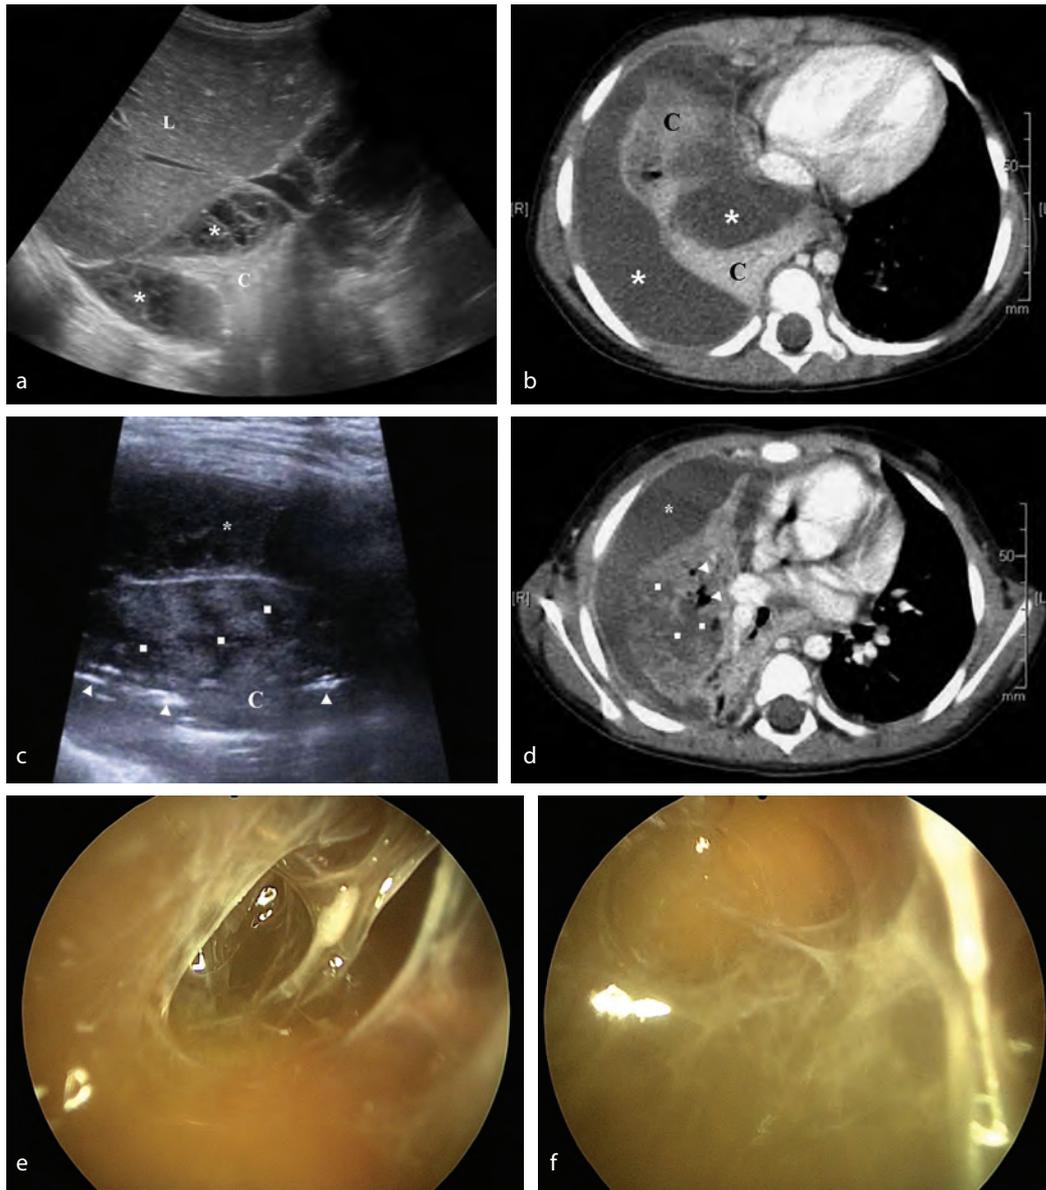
A 3-year old girl who was treated as an outpatient for 8 days by a local pediatrician, receiving antibiotic therapy for 5 days, was admitted to the Pediatric Emergency Department with tachypnea, tachycardia, and fever (38.3°C). Auscultation showed asymmetric breath sounds, and both early and late inspiratory crackles on the right. Lung ultrasound (a, c) and CT performed the next day (b, d) showed lung consolidations (C) with necrotic areas (□) and a small amount of air (arrow heads), as well as massive pleural effusion (*). However, lung ultrasound, unlike CT, detected numerous fibrin strands within the pleural effusion. L - liver. e, f) Video assisted thoracoscopy confirmed the ultrasound finding of multiple fibrin strands within the pleural space.
